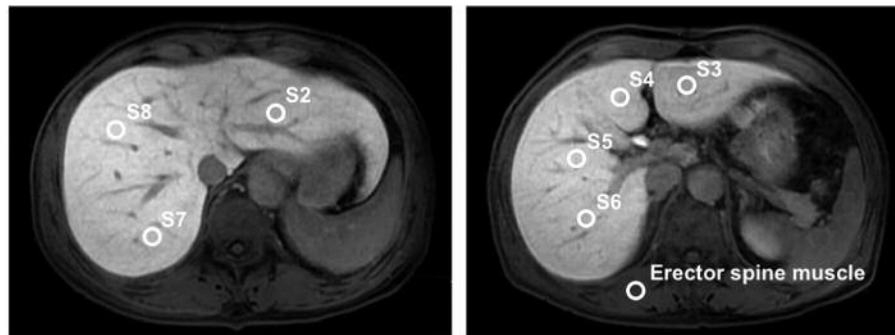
The signal intensities in magnetic resonance images of the liver parenchyma were calculated by setting the seven regions of interest according to Couinaud's segments.
